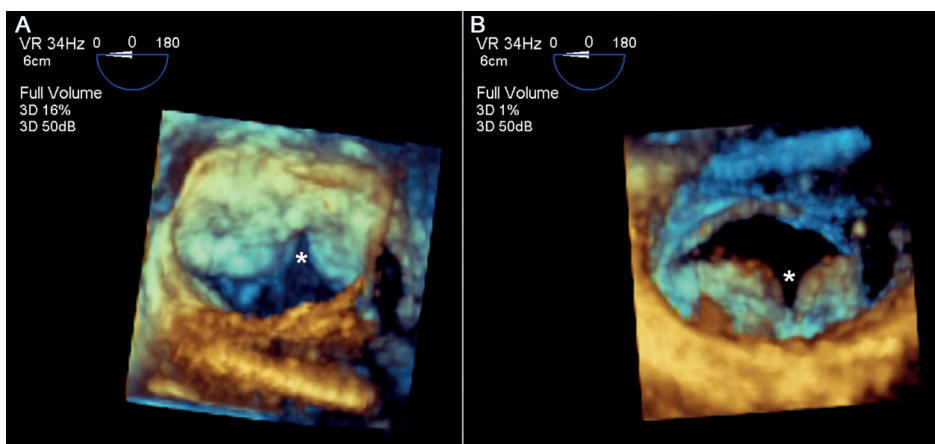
Three-dimensional echocardiographic surgical view of an anterior mitral valve leaflet cleft seen from the left atrial (surgical) view (A, see asterisk) and left ventricular view (B, see asterisk).
